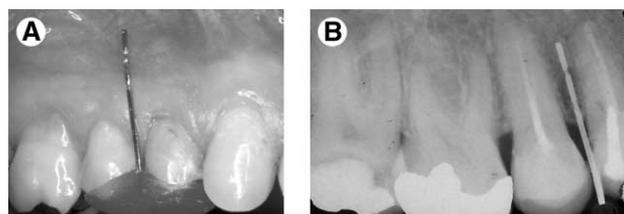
Miniscrew placement guide. (A) Surgical guide. (B) Radiographic evaluation of intended screw placement site.
